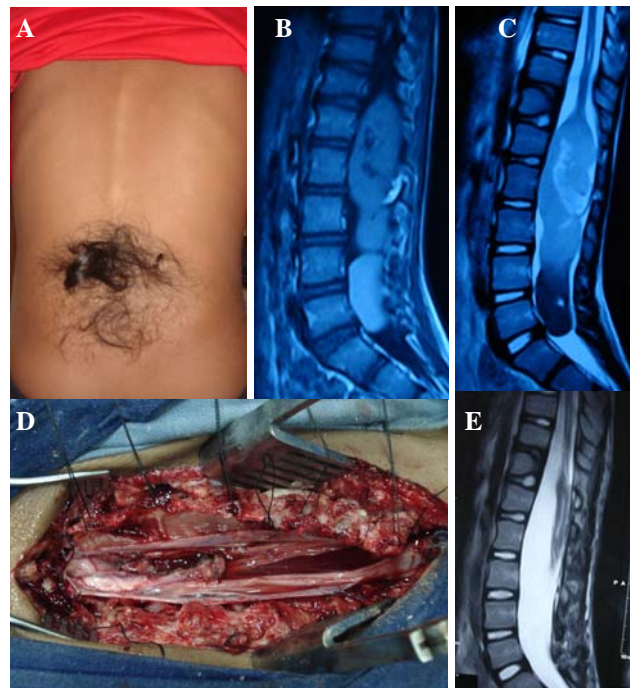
A) Hypertrichosis, B) Pre operative T1W MRI, C) Pre operative T2W MRI, D) Intra operative picture showing complete excision of tumor, E) Post operative T2W MRI showing complete excision.
